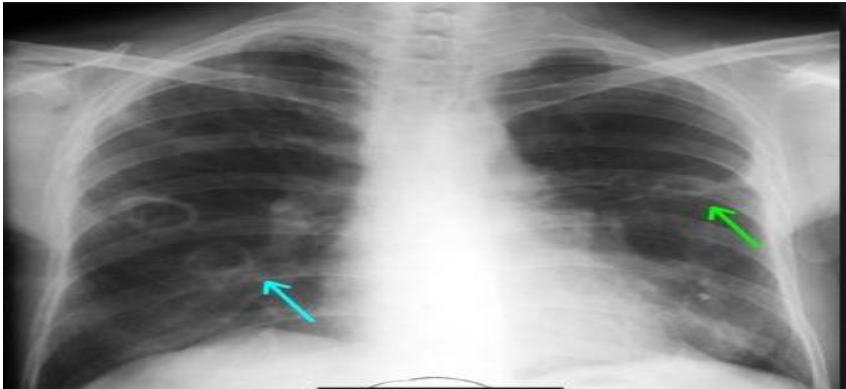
A radiograph showing abnormalities in the lung of TB patient
